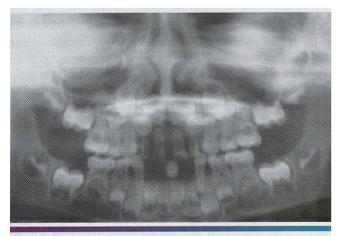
• Hypophosphatasia. This panoramic radiograph shows the loss of the mandibular anterior teeth. (Courtesy of Dr. Jackie Banahan.)
